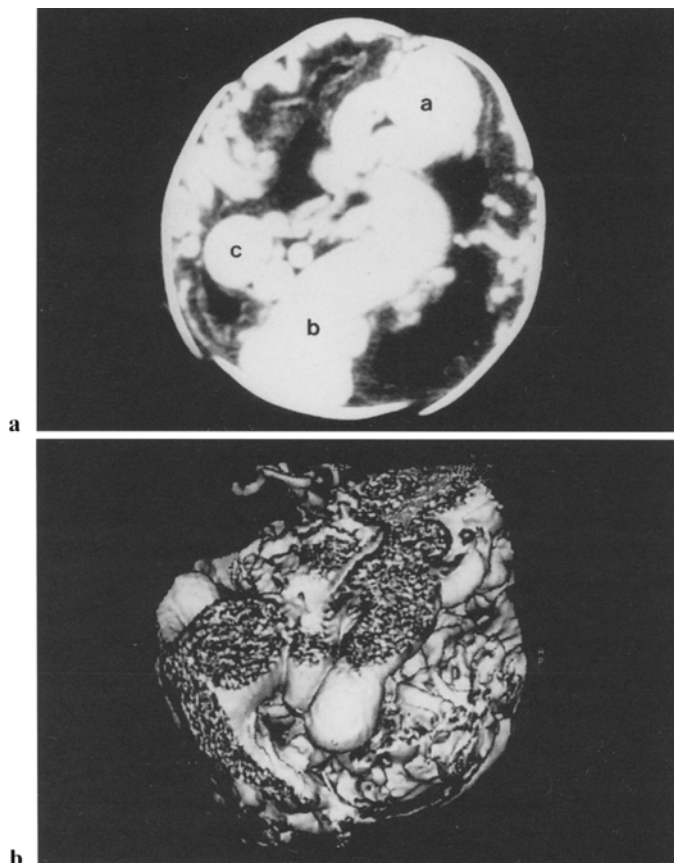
Two-dimensional a and three-dimensional b computed tomographic images. *a*, *b*, and *c* represent three large aneurysms, and numerous aneurysms are seen in the images
